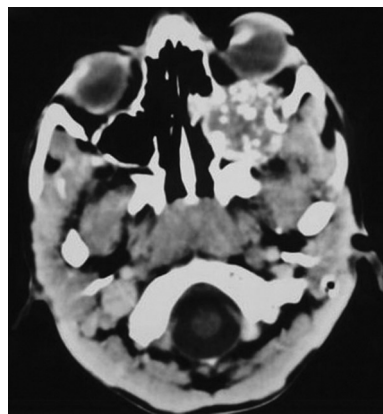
Computed tomographic scan of the paranasal sinuses (axial view) showing a nonenhancing expansile, lobulated heterogeneous mass with multiple internal calcifications. The mass has extended to the orbit, causing proptosis.
